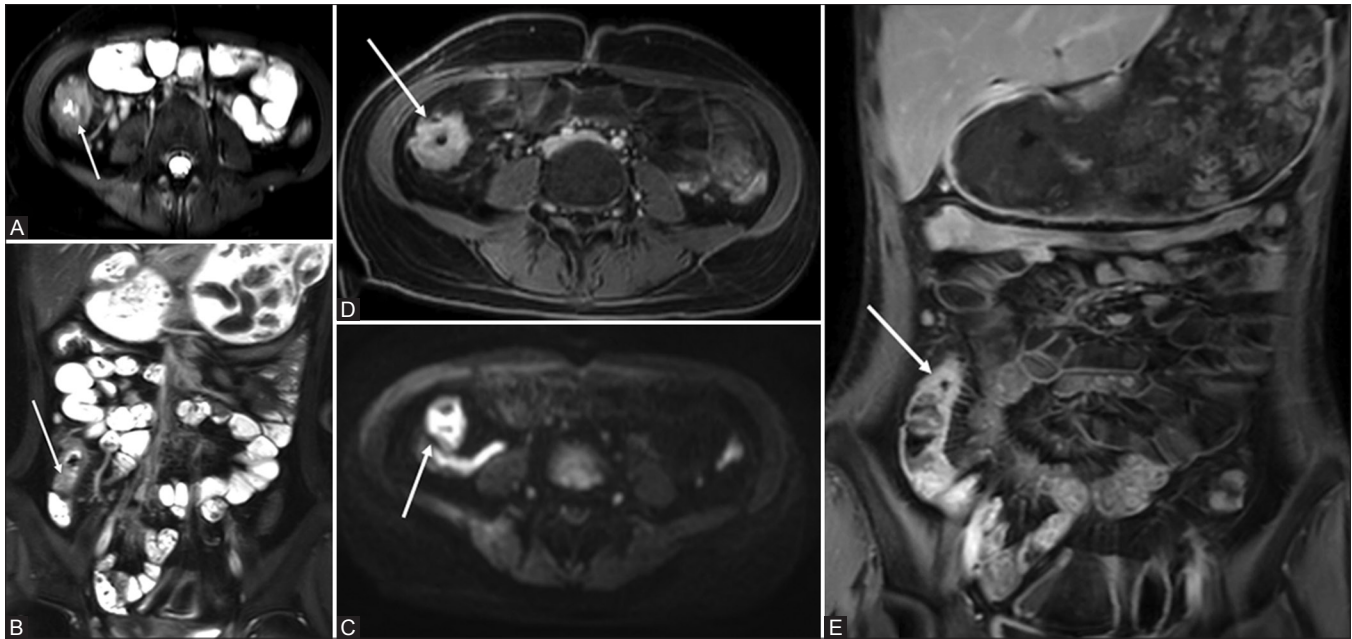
(A-E): Active CD. MRE images showing wall thickening at ileocecal junction (thin arrow) which is hyperintense on T2-weighted images (A and B), shows restricted diffusion on diffusion weighted image (C), and intense enhancement on postcontrast T1 weighted images (D and E). There is associated increased mesenteric vascularity (comb sign) along the mesenteric border of the involved bowel segment. These features are suggestive of active inflammatory stage in CD
